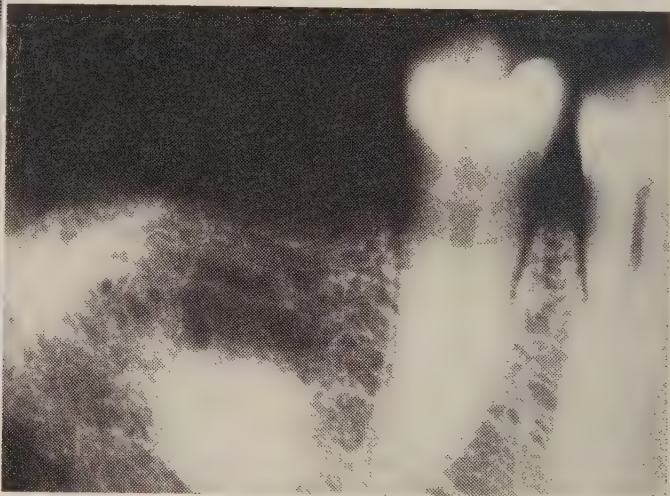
Radiograph shows granular bone, directional change of the trabeculae and a round area of dense bone in the posterior part of the maxilla.
